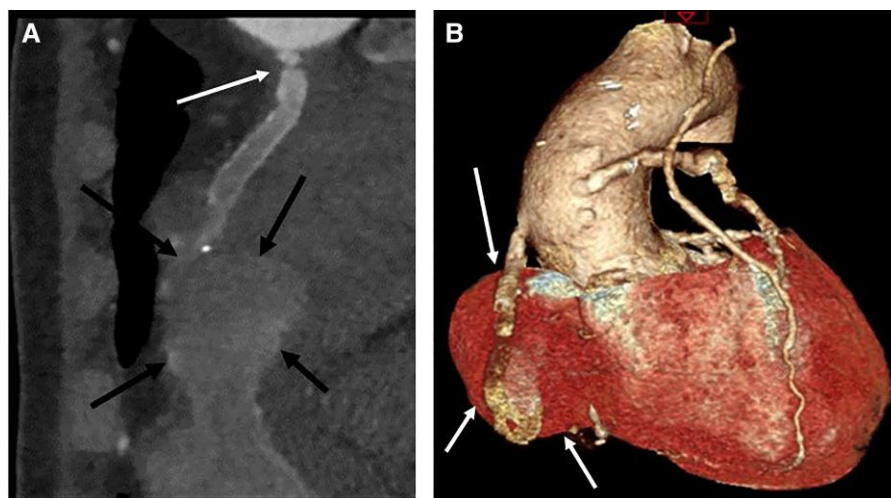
(A) Cardiac computed tomography showing calcified, diseased saphenous vein graft with critical proximal stenosis (white arrow). Large calibre distal aneurysm measuring 5.9 cm in maximal diameter (black arrows). Thrombosed with no contrast enhancement of distal right coronary artery. (B) 3D reconstruction showing exact size and location of large saphenous vein graft aneurysm.
